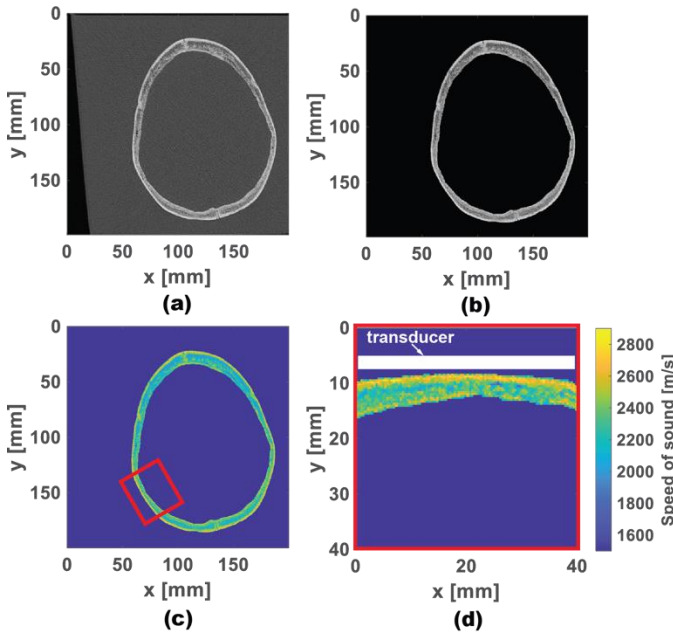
(a) A representative slice of the CT scan of an *ex vivo* human skull. (b) A processed CT image with the skull segmented from the background. (c) The SOS map derived from (b) with a 40-mm-long skull segment indicated by the red rectangular box. (d) The 40-mm-long segment after rotation.
